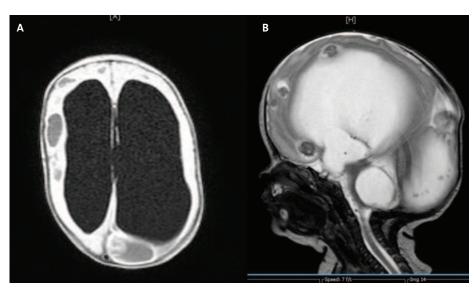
(A) T1 (coronal) and (B) T2 (sagittal) magnetic resonance images (MRIs) of the brain taken after five weeks of therapy with intravenous liposomal amphotericin B and fluconazole showing multiple ring enhancing lesions located in intraventricular, periventricular and intraparenchymatous areas. There is also hydrocephalus, secondary to bilateral grade IV intraventricular haemorrhage.
